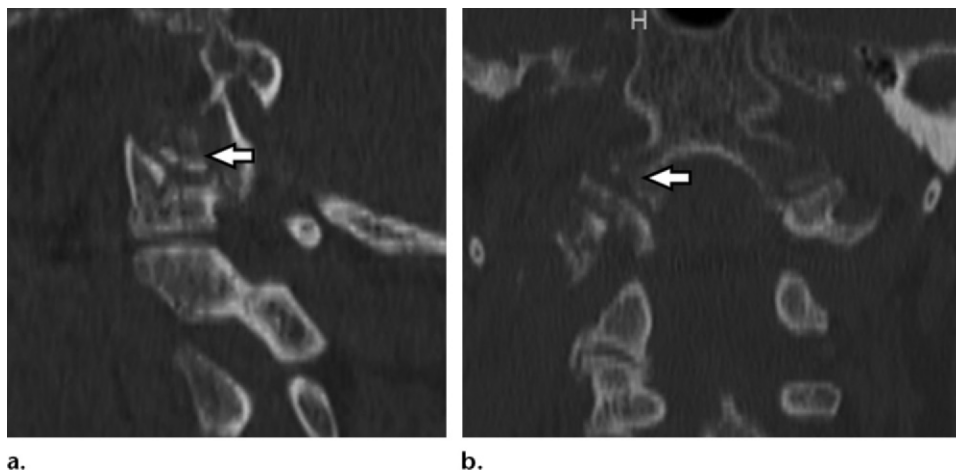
Anderson and Montesano type I occipital condyle fracture. Sagittal (a) and coronal (b) CT reformations of the same patient demonstrate the extent of the comminuted fracture (arrow) of the right occipital condyle.
